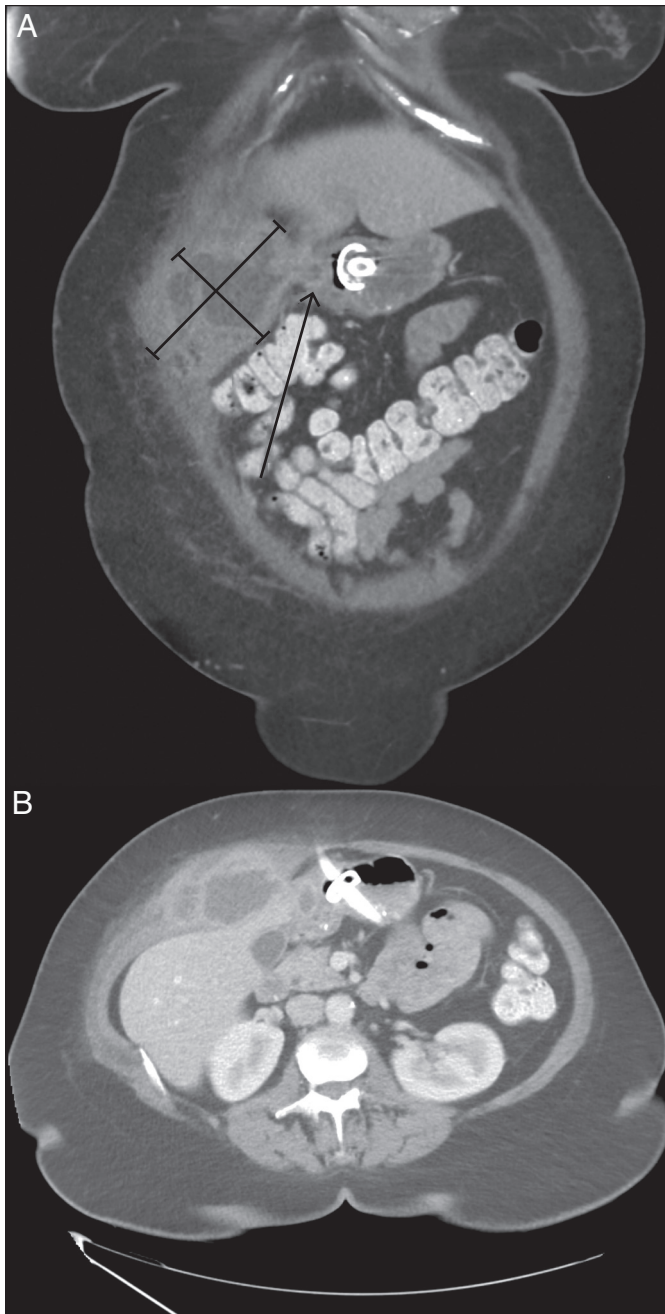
(A) Coronal and (B) axial views of abdominal computed tomography revealing a thick-walled, hypodense, homogeneous, cystic mass without internal calcifications or gas, which was centered in the right anterior abdominal wall musculature. The mass was emerging from gastric mucosa (arrow) and compressing the adjacent intraperitoneal liver and bowel.
